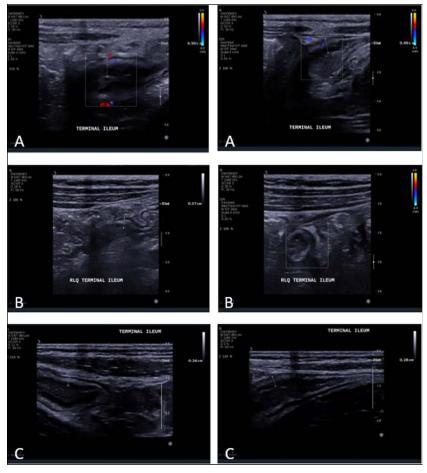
(A) Intestinal ultrasound at 10/40 gestation, increased bowel wall thickness of 5 mm, and hyperemia on color Doppler (Limberg score 2). (B) Intestinal ultrasound at 20/40 gestation, bowel wall thickness of 3.7 mm, and no hyperemia on color Doppler (Limberg score 1). (C) Intestinal ultrasound at 3 months of postpartum, normal bowel wall thickness, and no hyperemia on color Doppler (Limberg score 0). We acknowledge Dr Emma Flanagan for performing the initial intestinal ultrasound examinations and providing images for (A) and (B).
